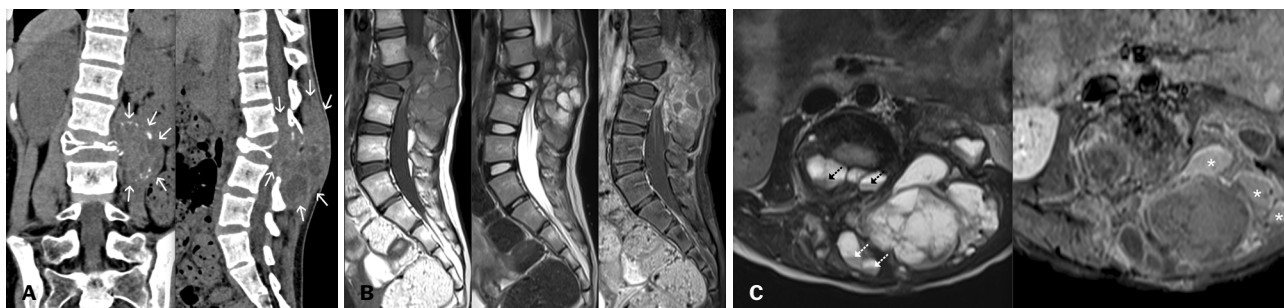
GCT in a 12-year-old girl. In A, coronal and sagittal CT images showing marked asymmetric collapse of L3 and a large mass arising from the posterior elements with a bulky left-sided soft-tissue component (straight arrows) extending into the spinal canal; there was no tumor matrix calcification (only peripheral shell-like osseous fragments), although there were internal areas of hypodensity. Sagittal T1WI, T2WI, and contrast-enhanced fat-suppressed T1WI (B), together with axial T2WI and contrast-enhanced fat-suppressed T1-WI (C), showing near-complete canal obliteration by a heterogeneously enhancing solid component with additional cystic areas, some with fluid–fluid levels (dashed arrows), with or without hemorrhagic content that is intrinsically hyperintense on T1WI (asterisks), showing peripheral/septal enhancement, corresponding to ABC-like changes.
